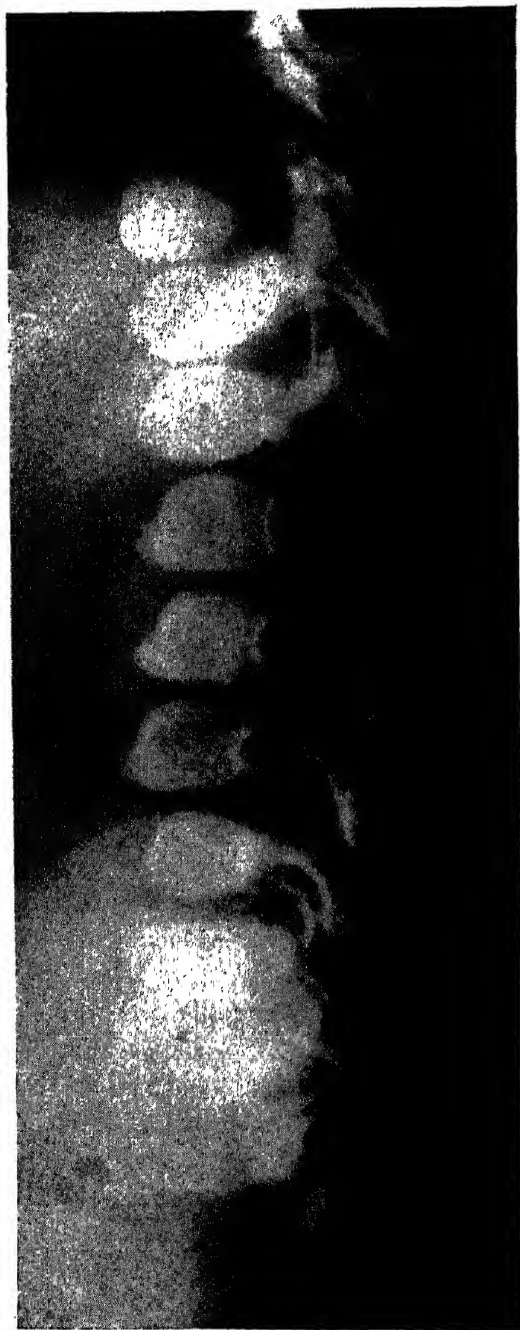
Gargoylism. Lateral roentgenogram of spine of 3-year-old boy showing the marked anterior-inferior beaking of the upper lumbar bodies, pathognomonic of this condition. (S. Larson and J. A. Lichty, Jr.: *Am. J. Roentgenol.*)
